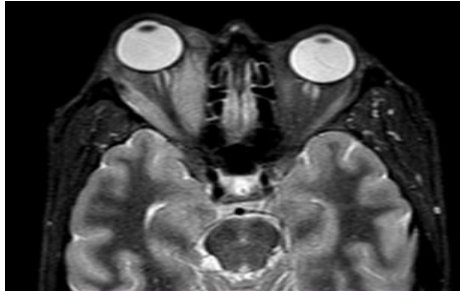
Axial T1(A), Axial T2(B), Axial FLAIR(C), Coronal T1 post contrast (D), Sagittal T1 post contrast(E): Diffuse enlargement of both lacrimal glands more evident on right side displayed low signal intensity at T1WI(A), high signal intensity at T2WI (B) with mild homogenous enhancement after IV contrast injection and just touching the lateral aspect of lateral rectus muscle on both sides with bilateral preseptal edema more on the right side and causing mild right eye proptosis. Axial DWI (F), Axial ADC (G): The lesion showed hyperintense signal on DWI (restricted diffusion), ADC value was $0.9 \times 10^{-3} \text{ mm}^2/\text{sec}$. MRI findings consistent with bilateral inflammatory orbital lesions versus lacrimal gland lymphoma. DW MRI showing that lesions had restricted diffusion which is consistent with bilateral lacrimal gland lymphoma
